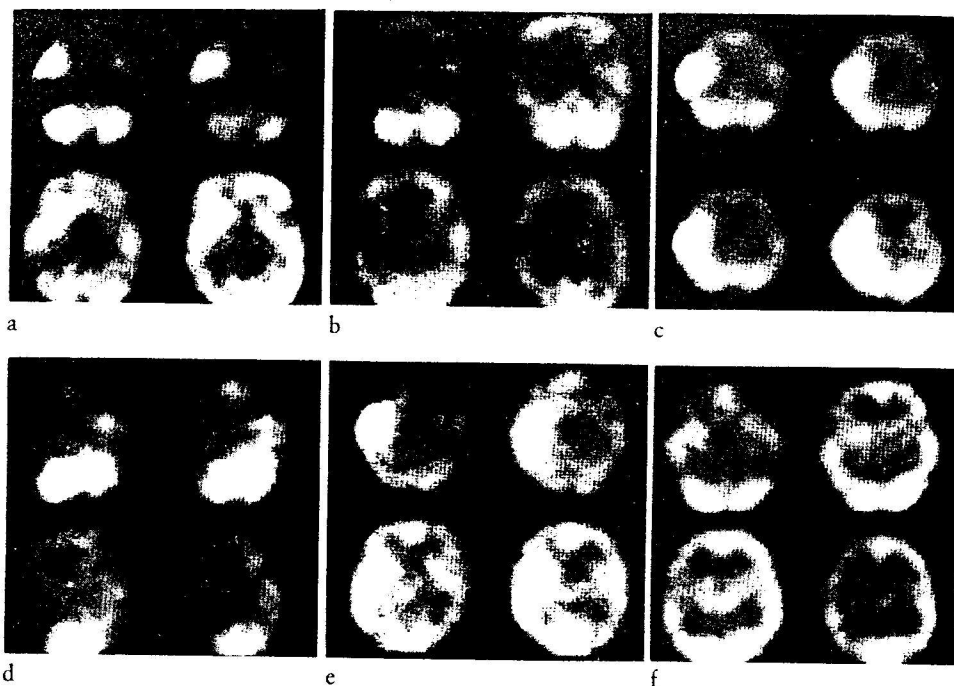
SPECT in HSVE. *Case 3* in the Table imaged with HM-PAO. a) A hyperperfused area is seen in the right temporal lobe 39 days after onset of encephalitis. b) The hyperperfusion has changed into hypoperfusion 91 days after the onset of encephalitis. *Case 1* in the Table imaged with IMP. c) An intensely hyperperfused area is seen in the right temporal lobe 8 days after onset of encephalitis. d) The area of hypoperfusion covers right frontal and temporal lobes 232 days after onset. This patient was also 59 and 163 days after onset, and gradual decrease of the hyperperfusion was seen. *Case 6* in the Table imaged with HM-PAO. e) An hyperperfused area in the right anterior and middle temporal lobe 4 days after onset of encephalitis. f) Hypoperfusion is seen 55 days after onset in the corresponding area where initial hyperperfusion was seen.
